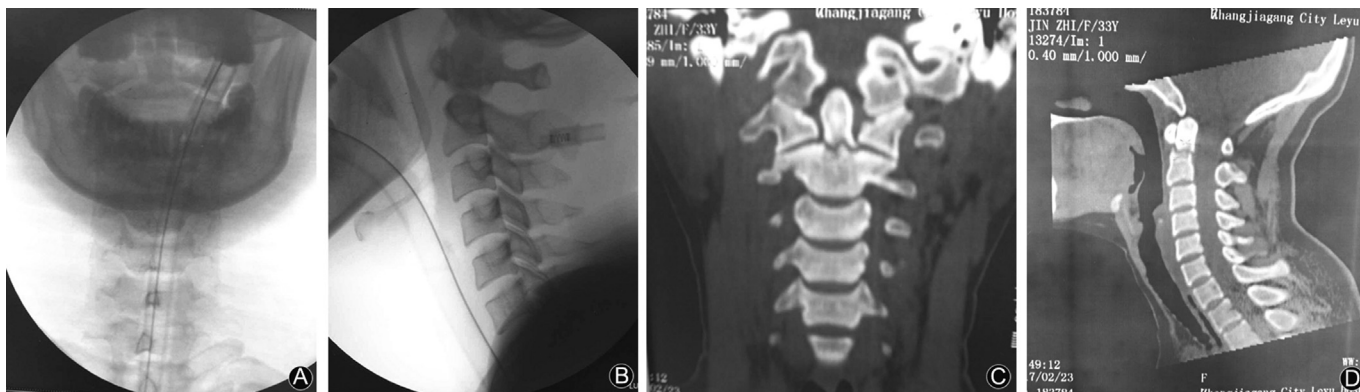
The pre-operative anteroposterior (A) and lateral (B) radiographs and computed tomography scan (C, D) showed type II odontoid fracture.
